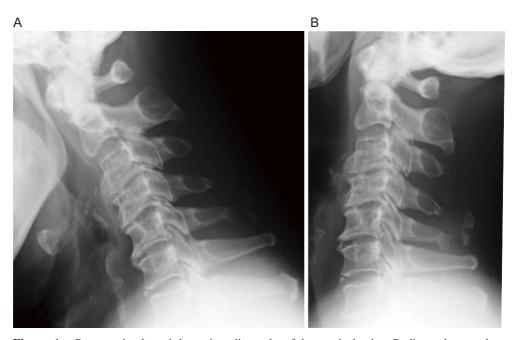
Preoperative lateral dynamic radiographs of the cervical spine. Radiographs reveal no joint instability at C1/2. (A) Flexed position. (B) Extension position.
